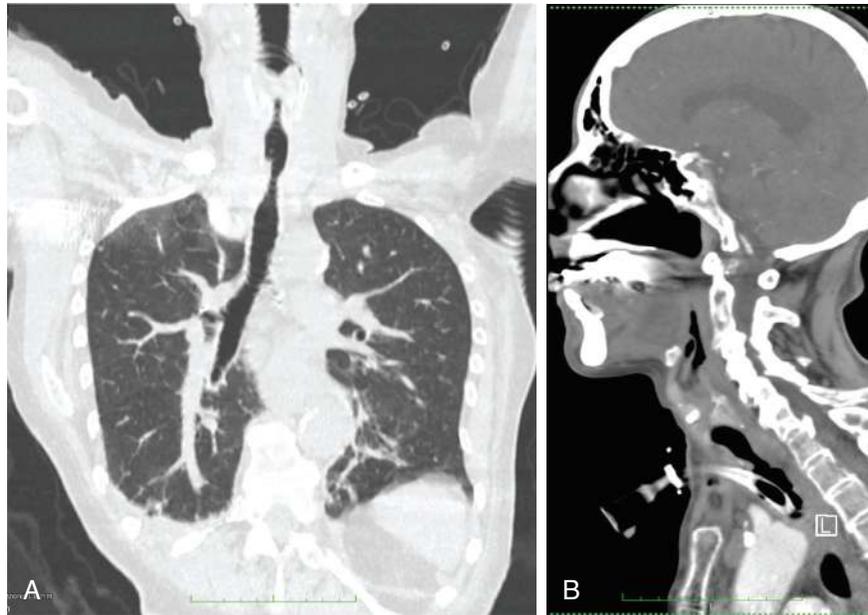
A, CT scan of very severe subglottic stenosis as a consequence of prolonged laryngeal intubation in a patient after cardiac arrest because of acute airway obstruction. B, CT scan of airway control by temporary tracheostomy in preoperative assessment.
